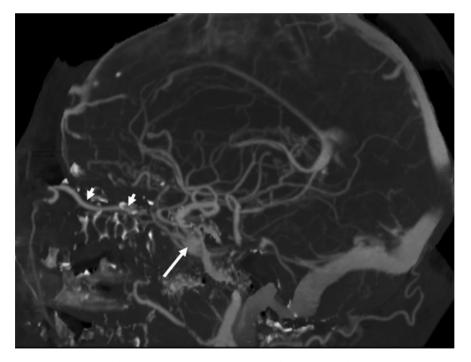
An 81-year-old woman with dural arteriovenous fistula at the left cavernous sinus. Selective maximum-intensity projection image of CTA with bone subtraction shows the left cavernous sinus (*arrow*) and the dilatation of the left superior orbital vein (*arrowheads*). Bony structures are partially visualized because of incompleteness of subtraction.
